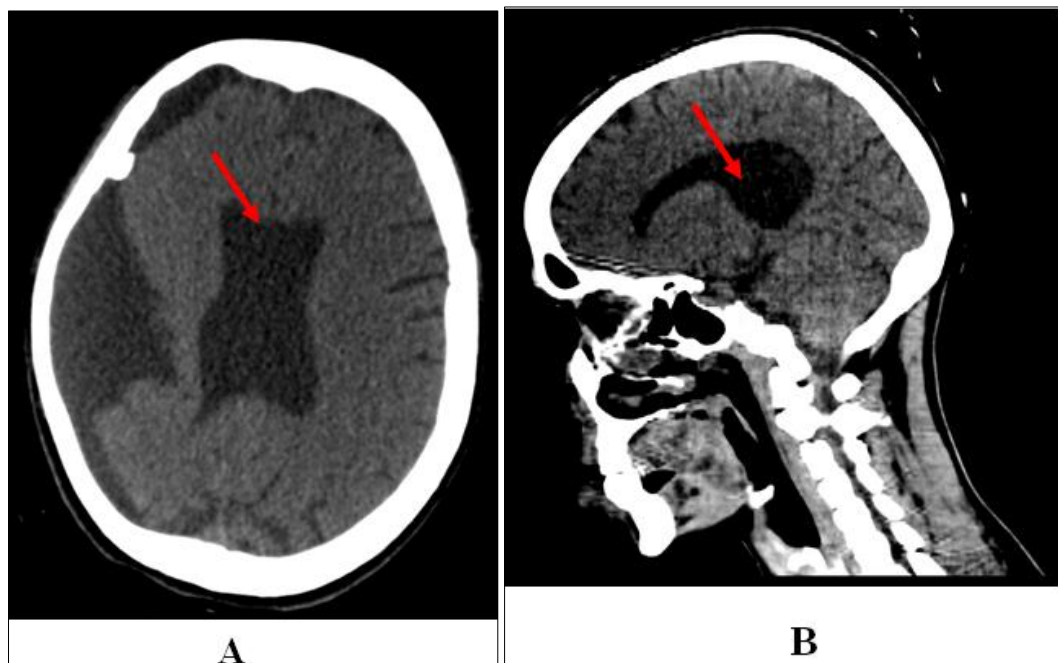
Cerebral CT scan without contrast injection in axial (A) and sagittal (B) sections, showing agenesis of the corpus callosum and septum pellucidum with dilation of the occipital horns, creating a bull's horn appearance (colpocephaly)
